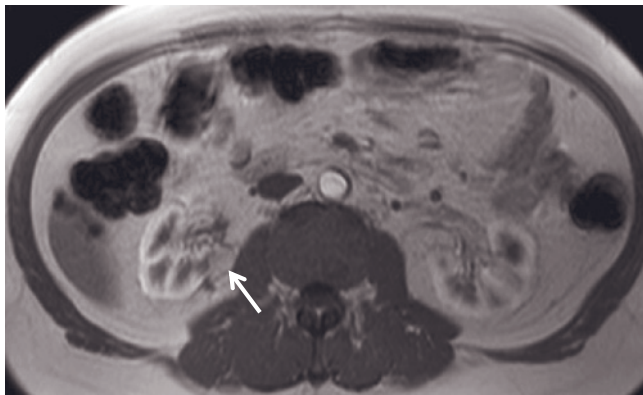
Renal mass after RF ablation. T2-weighted SS-ETSE (*a*), T1-weighted fat-suppressed gradient-echo (*b*), and immediate (*c*) and 90-s (*d*) postgadolinium T1-weighted gradient-echo images. An ablated area is seen in the midaspect of the right kidney, which appears as a region with central decreased signal and peripheral high signal intensity on the T2-weighted image (*a*) and central increased signal intensity and peripheral low signal intensity on the T1-weighted image (arrow, *b*) and shows a lack of enhancement on postgadolinium images (*c* and *d*), consistent with acute hemorrhage after successful RF ablation. Coronal
